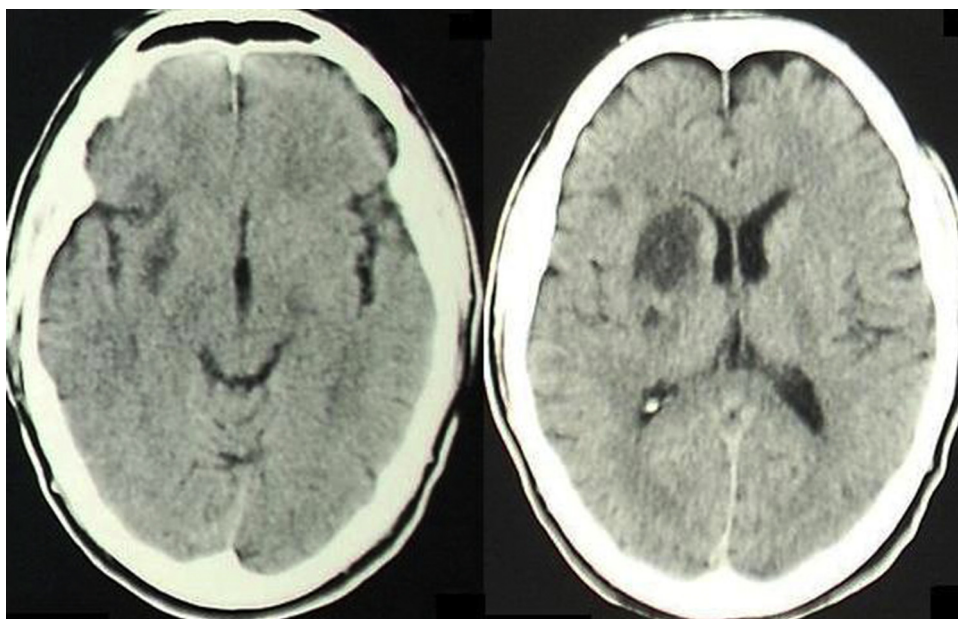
Forty-eight hours CT scan showing the ischemic lesion in the right anterior lenticular nucleus and small ischemic areas in the right insular-temporal cortex.
